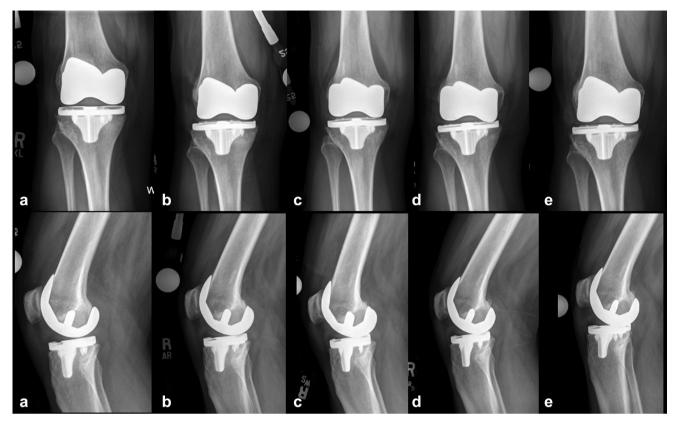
Progression of postoperative standing radiographs at (a) 6 mo, (b) 14 mo, (c) 2 y, (d) 5 y, (e) and 5.5 y demonstrating progressive posteromedial polyethylene wear.
